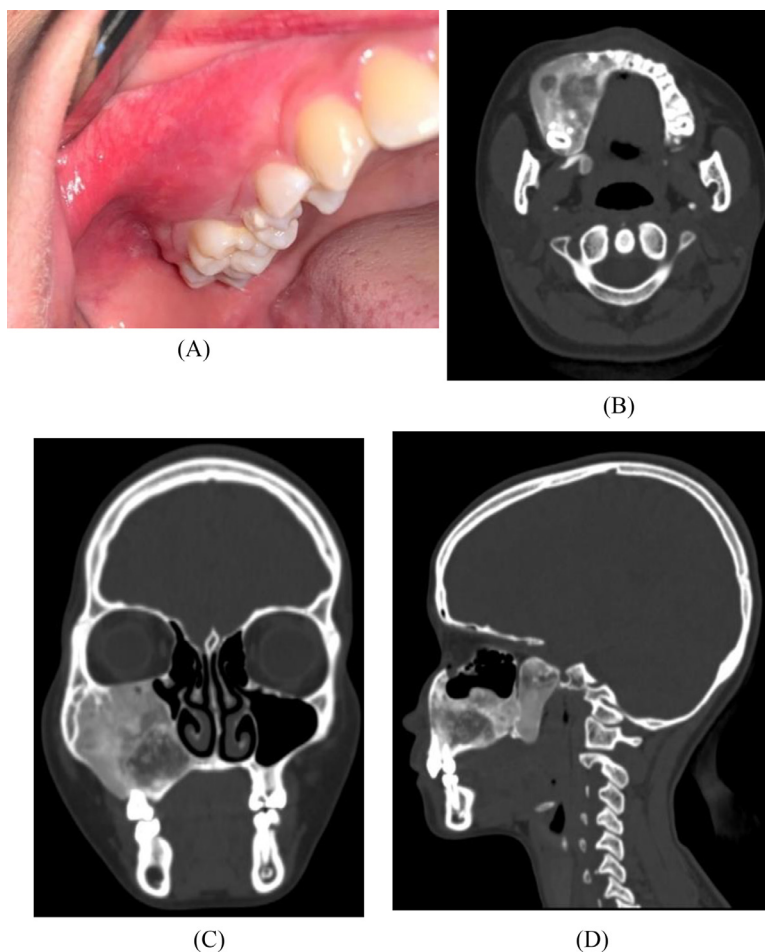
Ossifying fibroma. (A) Intraoral inspection shows a slow-growing lesion of the right maxilla. (B) Noncontrast axial CT image demonstrates extensive bone expansion with intact cortex and corticomedullary differentiation of the right maxilla to alveolar process with a clear margin, (C) noncontrast coronal CT image and (D) noncontrast sagittal CT image demonstrates diffuse radiopaque lesion with a mixed bone density characteristic filling the maxillary region extending to the infraorbital and lateral nasal.
